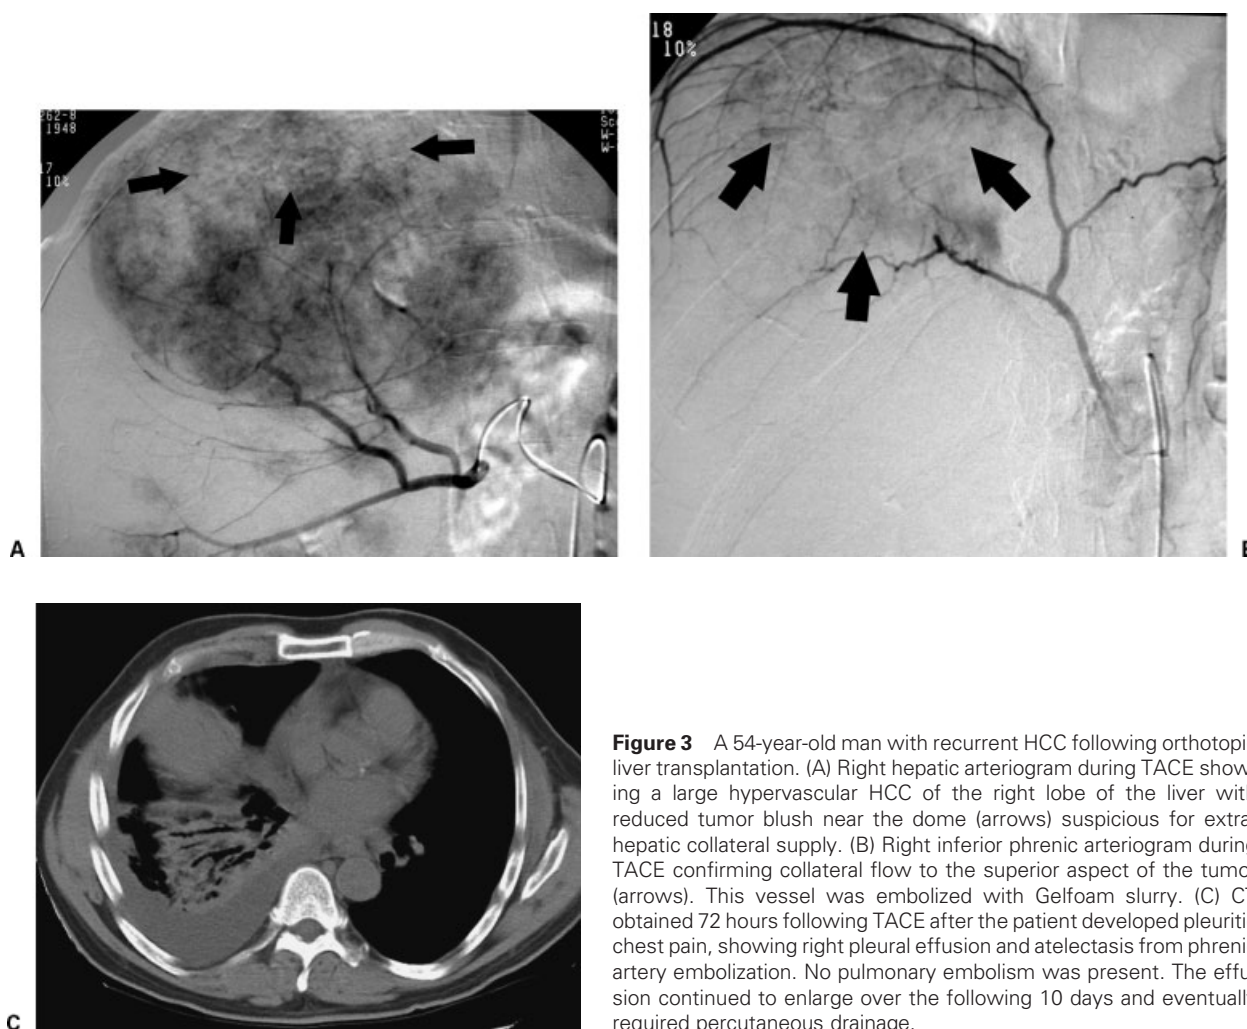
A 54-year-old man with recurrent HCC following orthotopic liver transplantation. (A) Right hepatic arteriogram during TACE showing a large hypervascular HCC of the right lobe of the liver with reduced tumor blush near the dome (arrows) suspicious for extrahepatic collateral supply. (B) Right inferior phrenic arteriogram during TACE confirming collateral flow to the superior aspect of the tumor (arrows). This vessel was embolized with Gelfoam slurry. (C) CT obtained 72 hours following TACE after the patient developed pleuritic chest pain, showing right pleural effusion and atelectasis from phrenic artery embolization. No pulmonary embolism was present. The effusion continued to enlarge over the following 10 days and eventually required percutaneous drainage.
